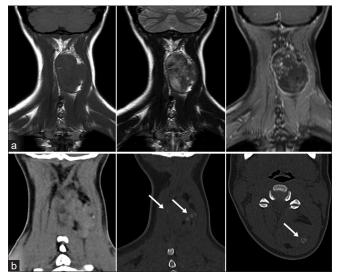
Neuroradiological findings. (a) Magnetic resonance imaging (from left to right): T1-weighted coronal view showing a hypo-isointense lesion of the posterior neck compartment; T2-weighted coronal view with the hyperintensity typical of these lesions; post-gadolinium coronal scan in which inhomogeneous contrast enhancement is evident. (b) Computed tomography scan (from left to right): Coronal view on soft-tissue sequences, coronal and axial view on bone sequences showing an isodense mass in the posterior compartment of the neck, containing calcifications (white arrows)
